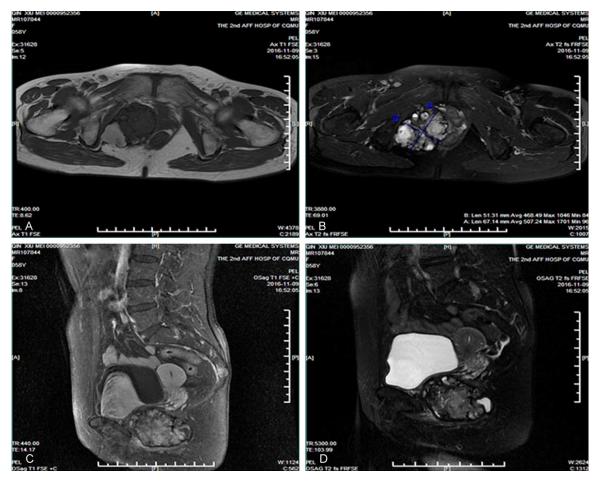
Pelvic magnetic resonance: A. Transversal T1-weighted magnetic resonance image. B. Transversal T2-weighted magnetic resonance image. C. Sagittal T1-weighted magnetic resonance image. D. Sagittal T2-weighted magnetic resonance image.
